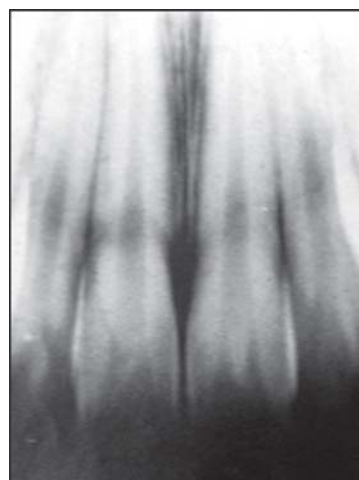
Elongation; this may be due to inadequate positive angulation of the radiographic beam or by failing to have the ala-tragus plane or occlusal plane parallel to the floor in the bisecting angle technique and then not using sufficient vertical angulation of the radiographic beam
